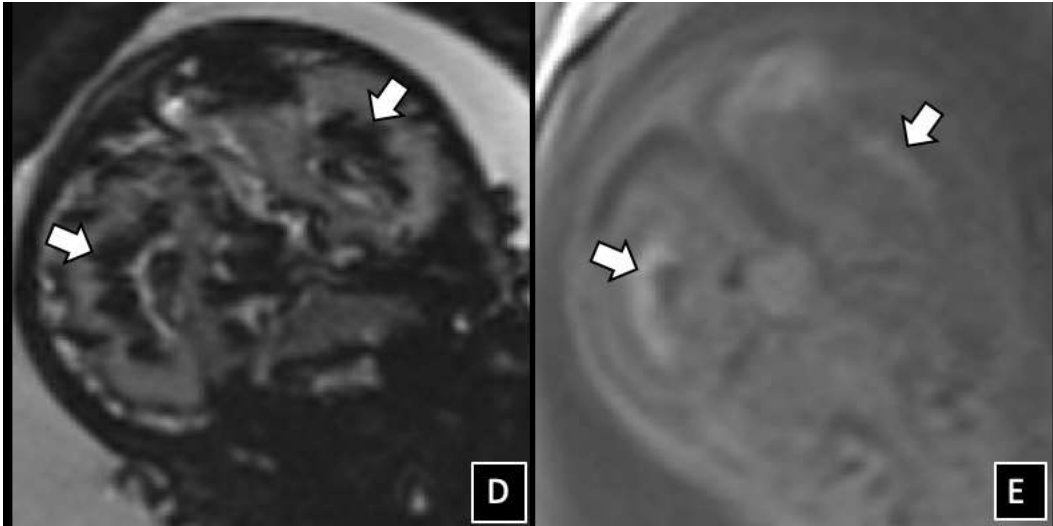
Parenchymal injuries in two fetuses with vein of Galen malformations. (A) Axial DWI image in a 31-week-old fetus shows restricted diffusion (arrow) in the left temporal lobe. (B) Coronal T2 SSFSE shows generalized volume loss, cystic change (black arrow), and T2 hyperintense signal (white arrows), related to encephalomalacia. (C) axial T2\* echo-planar image in a different 24 week-old fetus shows hemorrhage in the left periventricular region.
